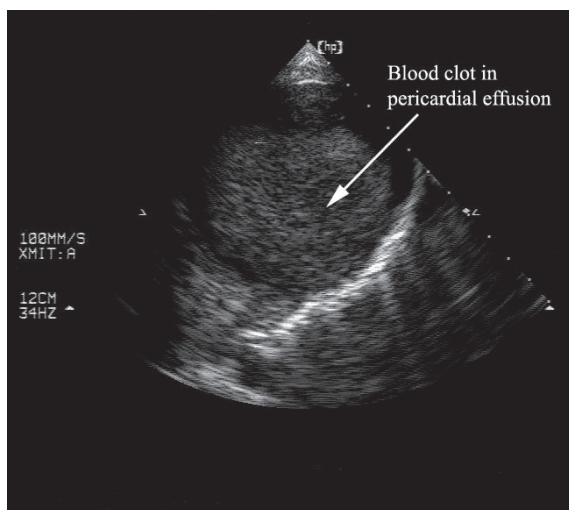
Bedside echocardiogram shows a blood clot in the pericardial effusion.
